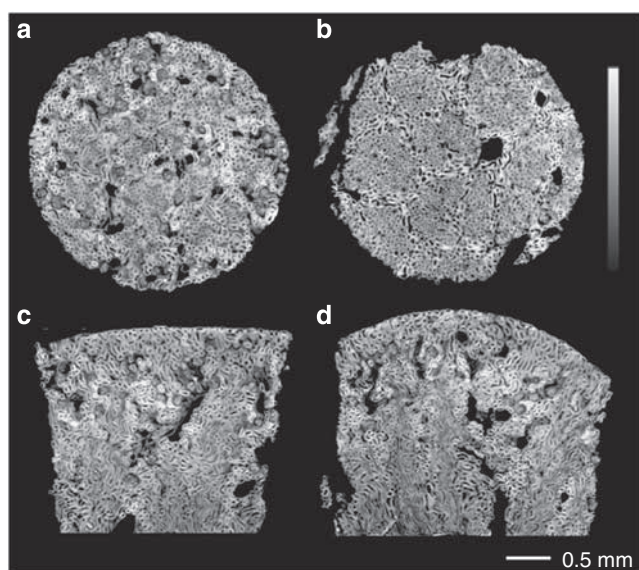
X-ray phase-contrast microtomographic images of a normal hamster. (a and b) 2D images of axial, (c) coronal, (d) and sagittal view. (a) Glomeruli, vessels, and various tubules are depicted clearly in the renal cortex, (b) whereas in the renal medullary area, the collecting tube and its surrounding vessels are seen as lobule-like patterns. (c and d) Proximal and distal tubules are shown as high density, and the collecting tubules in the medullary area (including medullary ray) are shown as low density.
